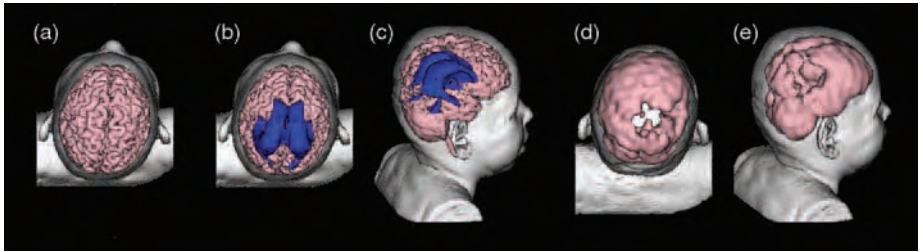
This child had hypoxic-ischemic brain injury at birth, with extensive cortical damage shown both structurally and functionally. This child's brain did not show adaptation, resulting in profound deficits at age four when the neuropsychological assessment and neuroimaging studies were performed. (a) Surface 3-D reconstruction depicting mild atrophy but otherwise more normal appearance of surface anatomy however, marked ventricular dilation is shown in (b) and (c) and SPECT imaging, rendered in 3-D surface maps demonstrate large gaps in cortical function (d and e).
